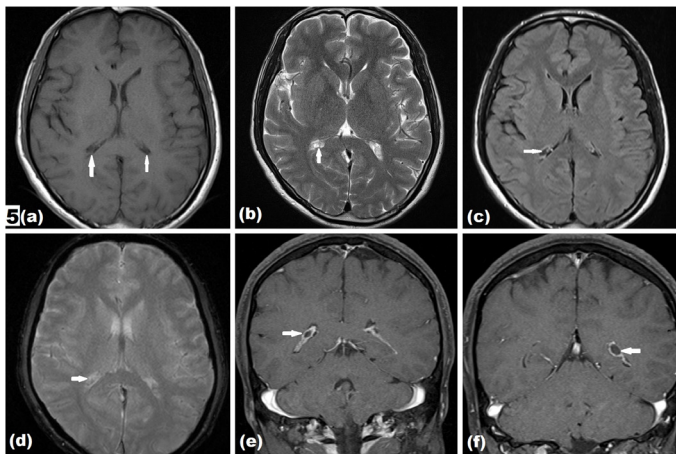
32-year-old-male with bilateral choroid plexus cysts. (a) T1WI. (b) T2WI. (c) FLAIR images showing fluid signal intensity cyst (arrows). (d) GRE showing no blooming. (e-f) Coronal post-contrast showing no enhancement of the cyst.]
